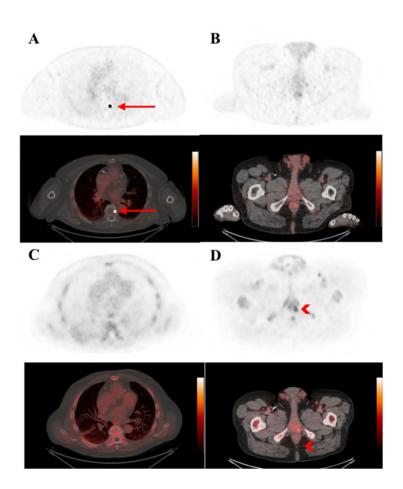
64 year-old man with BCR (PSA 3.1 ng/mL) had different findings on ¹⁸F-DCFPyL and ¹⁸F-Fluciclovine PET. Axial fused ¹⁸F-DCFPyL PET/CT (A bottom) and ¹⁸F-DCFPyL PET (A top), show focal uptake in the T7 vertebral body (arrow) but no uptake in prostate bed (B bottom - fused PET/CT images, B top - PET). In comparison, axial fused ¹⁸F-Fluciclovine PET/CT (C bottom) and ¹⁸F-Fluciclovine PET (C top) show no uptake in the T7 vertebral body but focal uptake (arrowhead) in the left aspect of the prostate bed (D bottom - fused PET/CT images, D top - PET).
